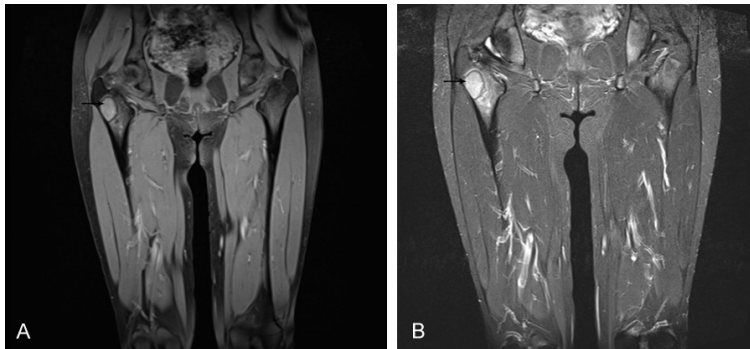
Thigh MRI scan revealed a low intensity in the T1 sequences (A) and at high intensity in the T2 sequences (B) with a size of about 2.2×2.2×3.2 cm (the superior and inferior diameter of left and right X) and irregular flakes around the focus. Contrast-enhanced scan showed that the above lesions had no obvious enhancement.
